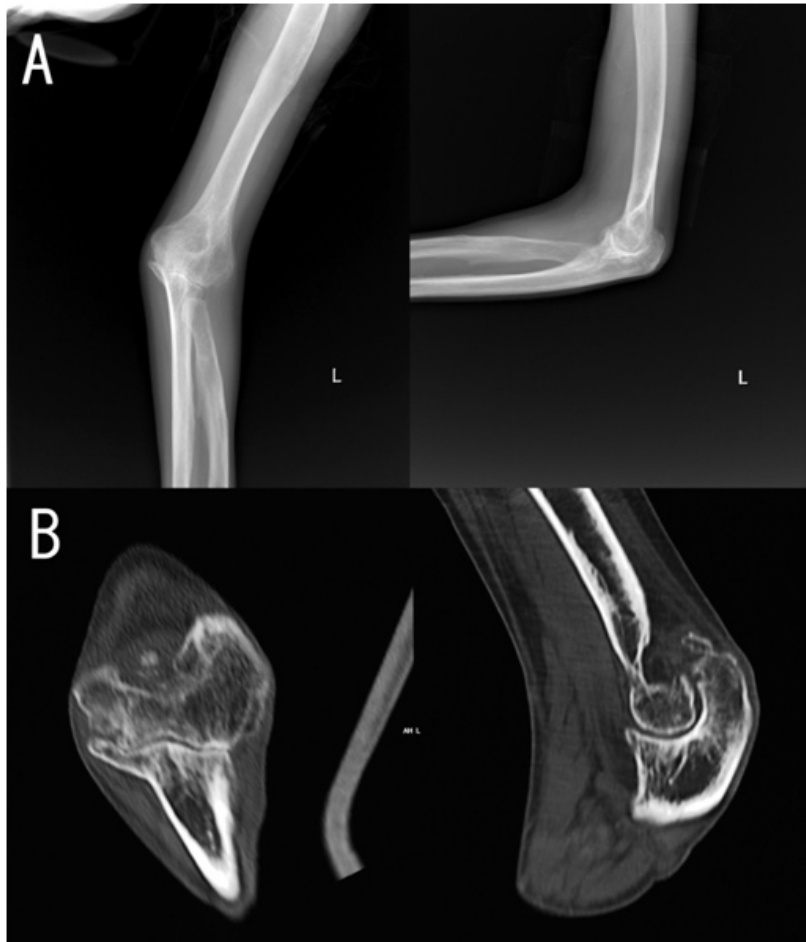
The X-rays and CT 40 years after IPA-O
